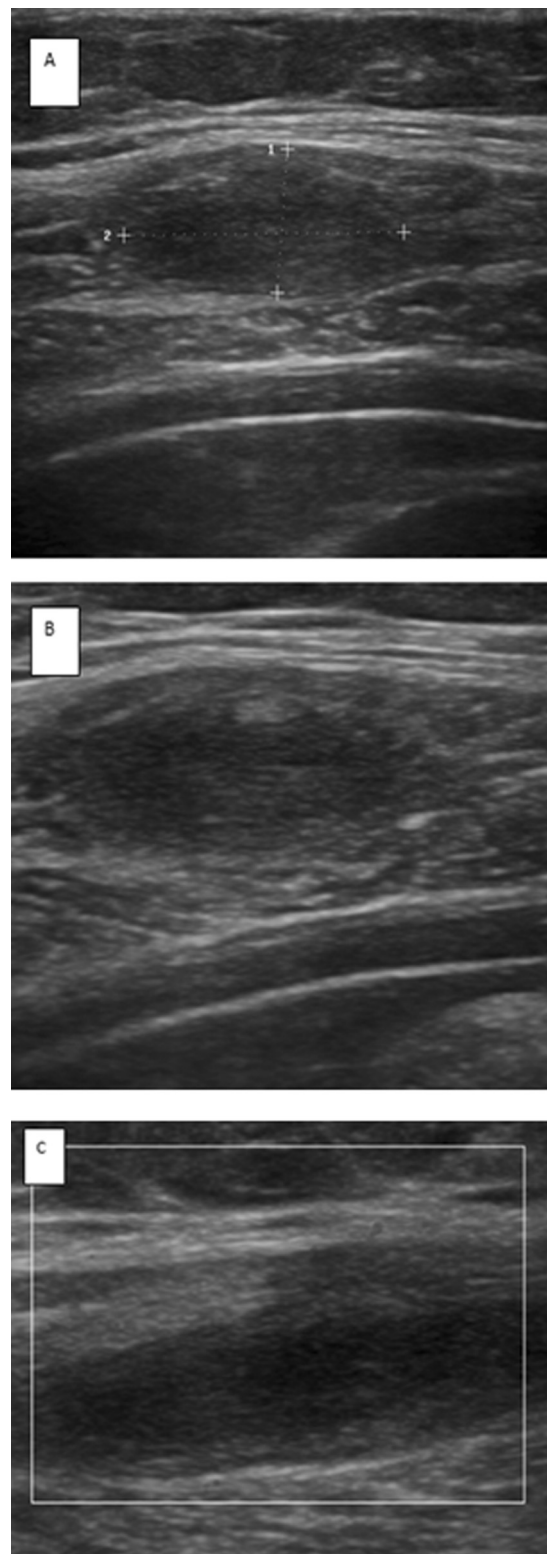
Ultrasound follow-up image 1 month post-percutaneous-aspiration-injection-reaspiration (PAIR) reveals reduction in size on the lesion, measuring $\sim 1.6 \times 0.7 \times 0.9$ cm on (A) longitudinal section, (B) transverse section, and (C) lesion shows no evidence of vascularity on color Doppler.
